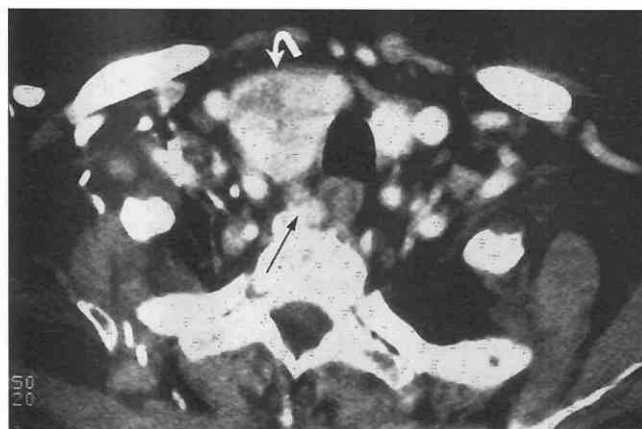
Axial postcontrast CT at the level of the clavicles shows an enhancing parathyroid adenoma (arrow) in the right tracheoesophageal groove. Goitrous enlargement of the right lobe of the thyroid can be visualized (curved arrow).
